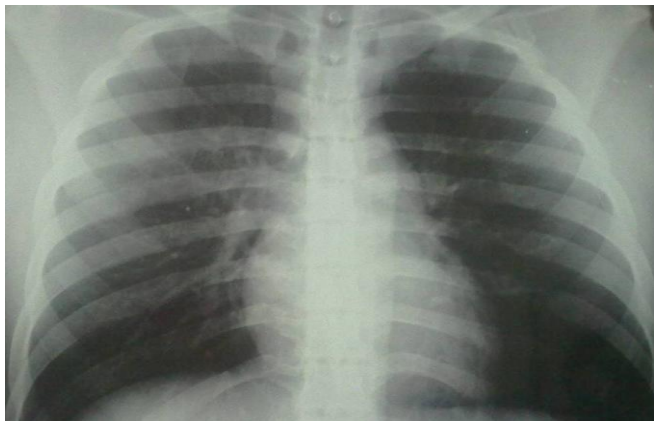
Chest X-ray after treatment showing clearance of lung fields
